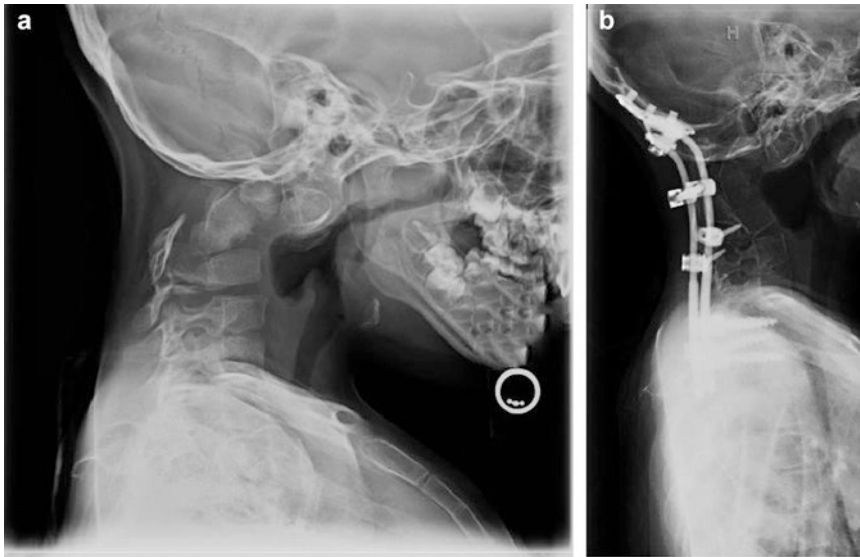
(a) Radiographs of a 6-year-old child with severe congenital cervical kyphosis. (b) Postoperative radiograph after patient underwent posterior spinal
